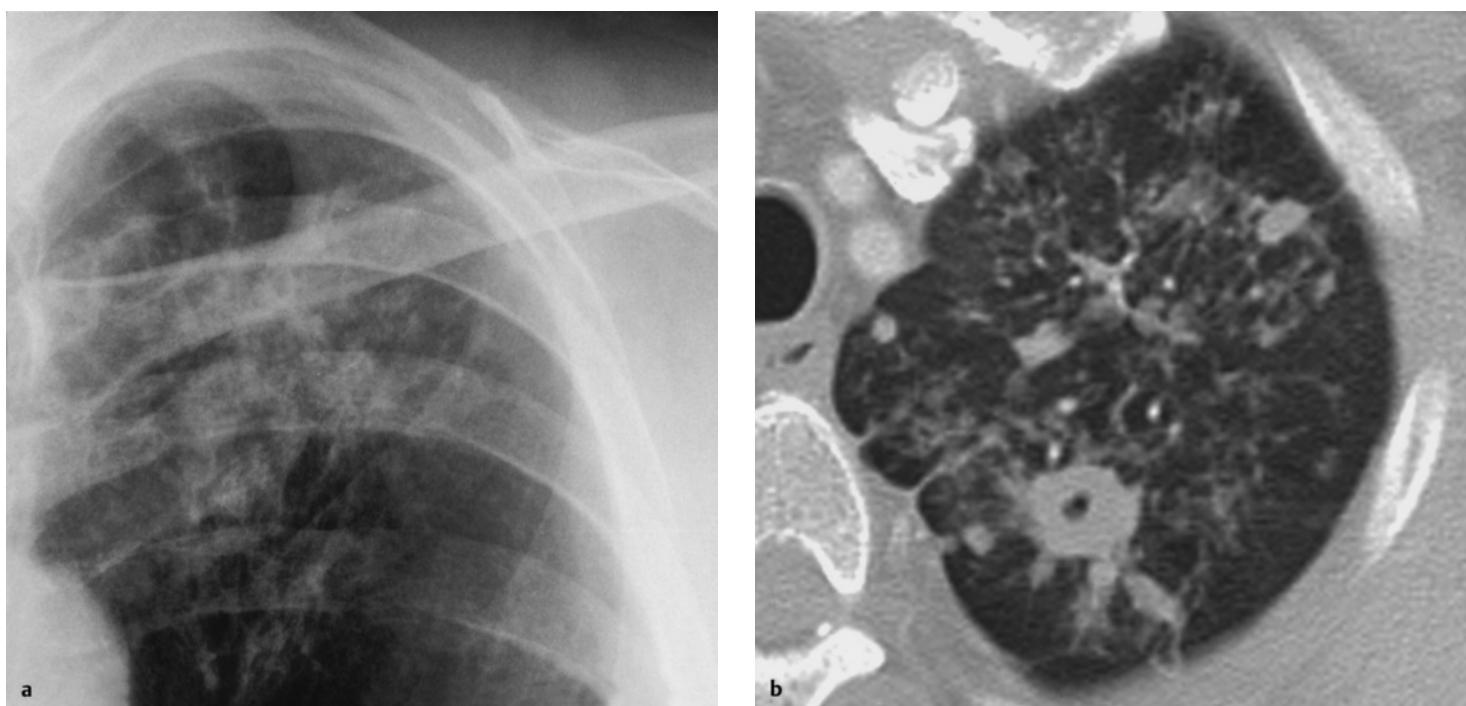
a–b Reactivated pulmonary tuberculosis. The detail enlargement (a) shows faint cloudy densities with the clavicle shadow in addition to sharply defined linear shadows and nodules. CT (b) confirms reactivation by demonstrating liquefaction.
